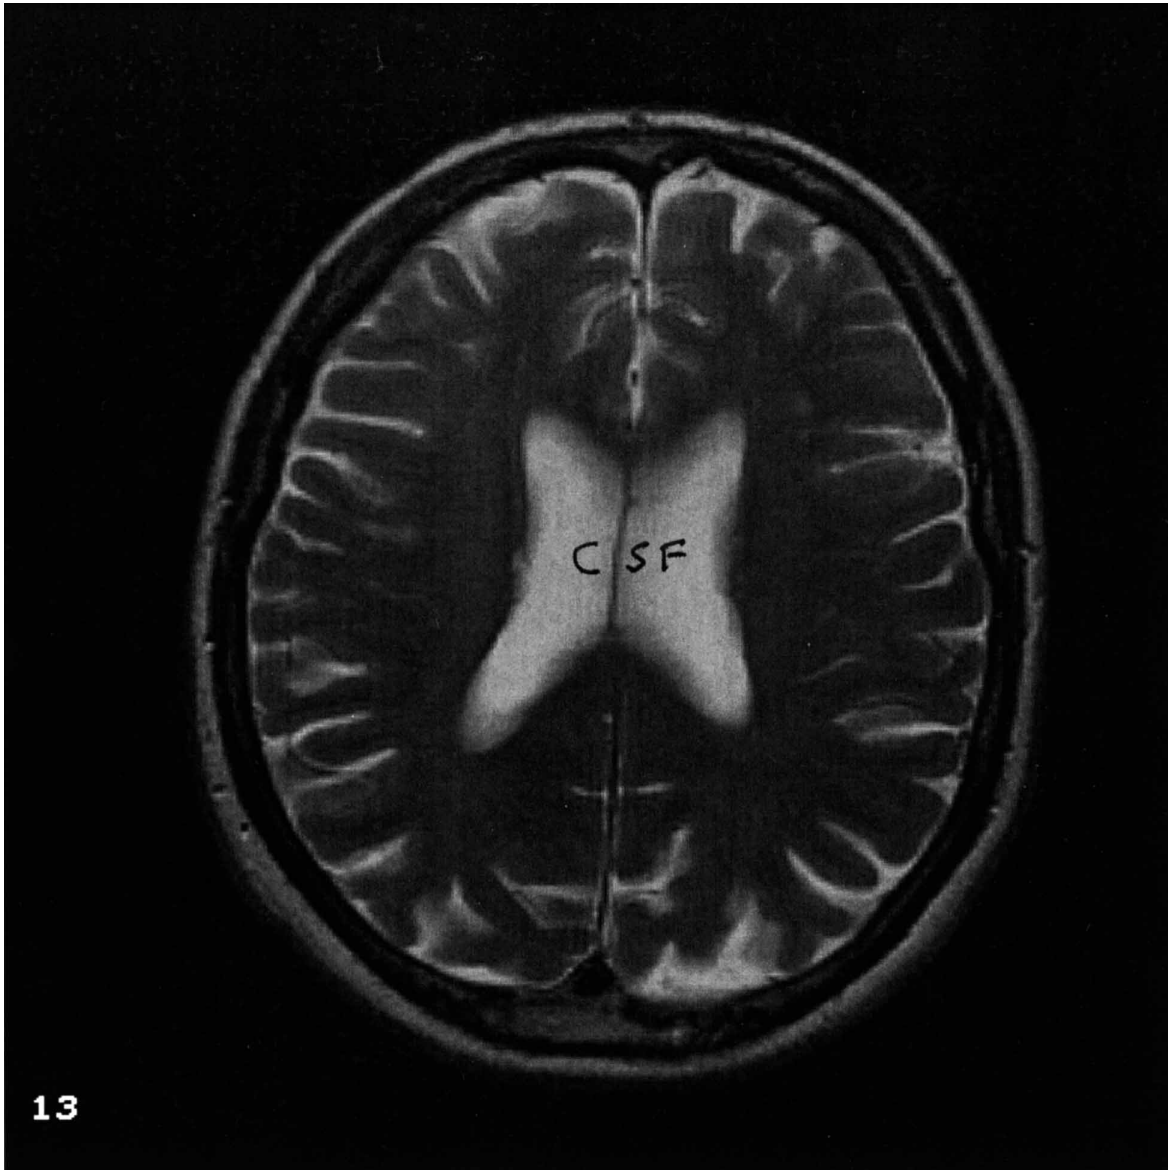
Ordered structure of the normal human brain. Magnetic resonance of a T2-weighted axial image at the level of the lateral ventricles which contain cerebro-spinal fluid (CSF) spread also thinly over the brain surface within the outer cranial bone. The neurons of the cerebral cortex form a superficial layer over the surface and extend into the convolutions, shown as white indentations. The myelinated axes for conduction occupy the remainder of the space (photograph by courtesy of Professor Joanna Wardlaw of the Department of Clinical Neurosciences, University of Edinburgh).
